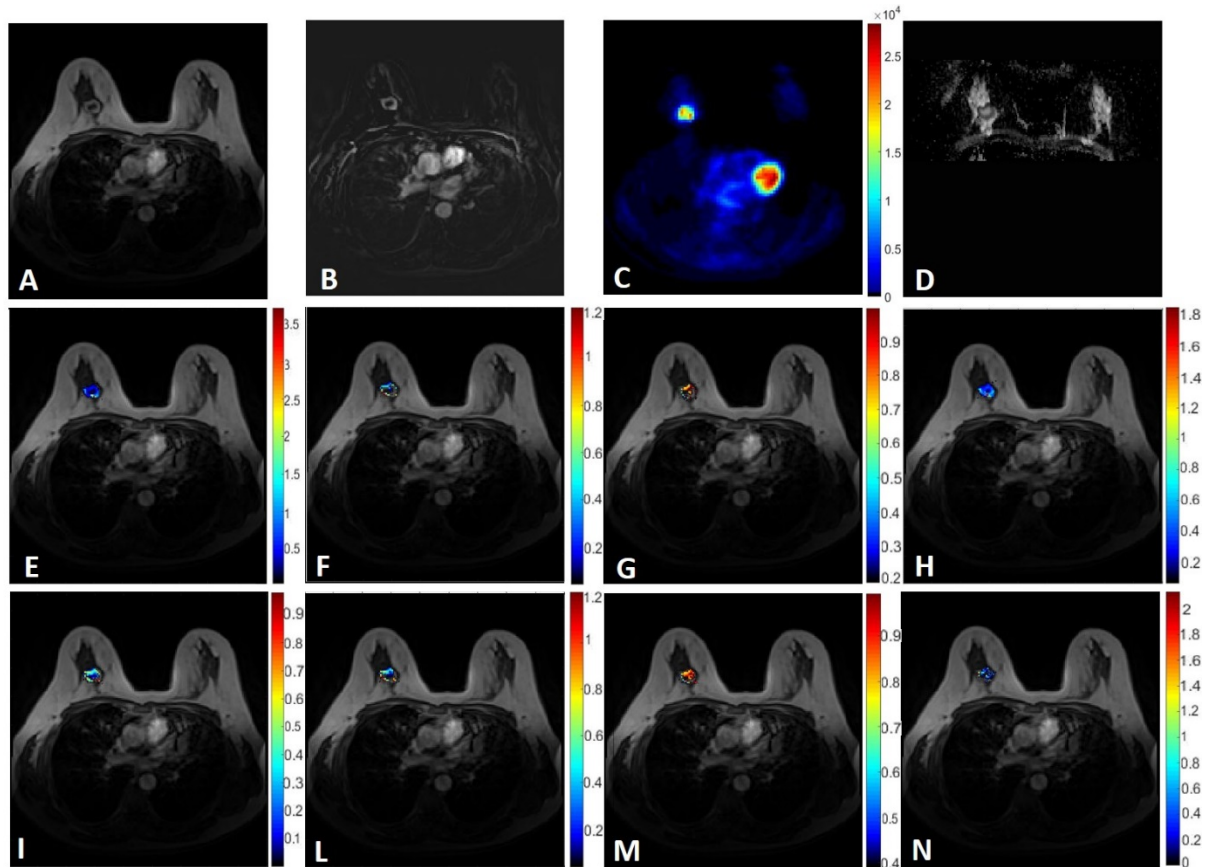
Patient n. 2; 45 years old, IDC. Representative axial images of a) post contrast MRI T₁-weighted image (8th phase); b) MRI subtraction of the baseline scan from the 8th phase; c) attenuation corrected PET image; d) ADC map; e - g) Pharmacokinetic maps evaluated with the Tofts model: K^{trans} , k_{ep} and v_e ; h) iAUC; i - n) Pharmacokinetic maps evaluated with the shutter speed model: K^{trans} , k_{ep} , v_e and τ_i .
